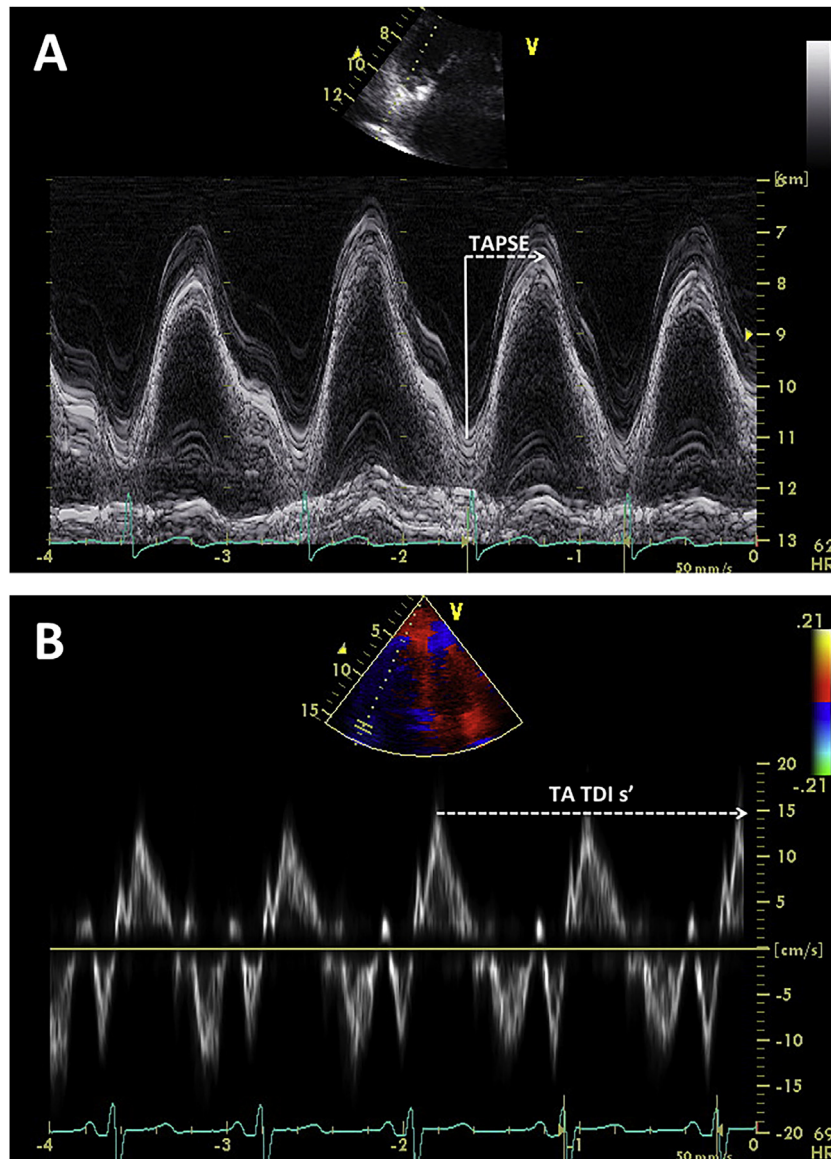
(A) Representative normal M-mode TAPSE recording with line and arrow demonstrating proper measurement. (B) Representative normal TA TDI s' Doppler signal with corresponding proper measurement.
